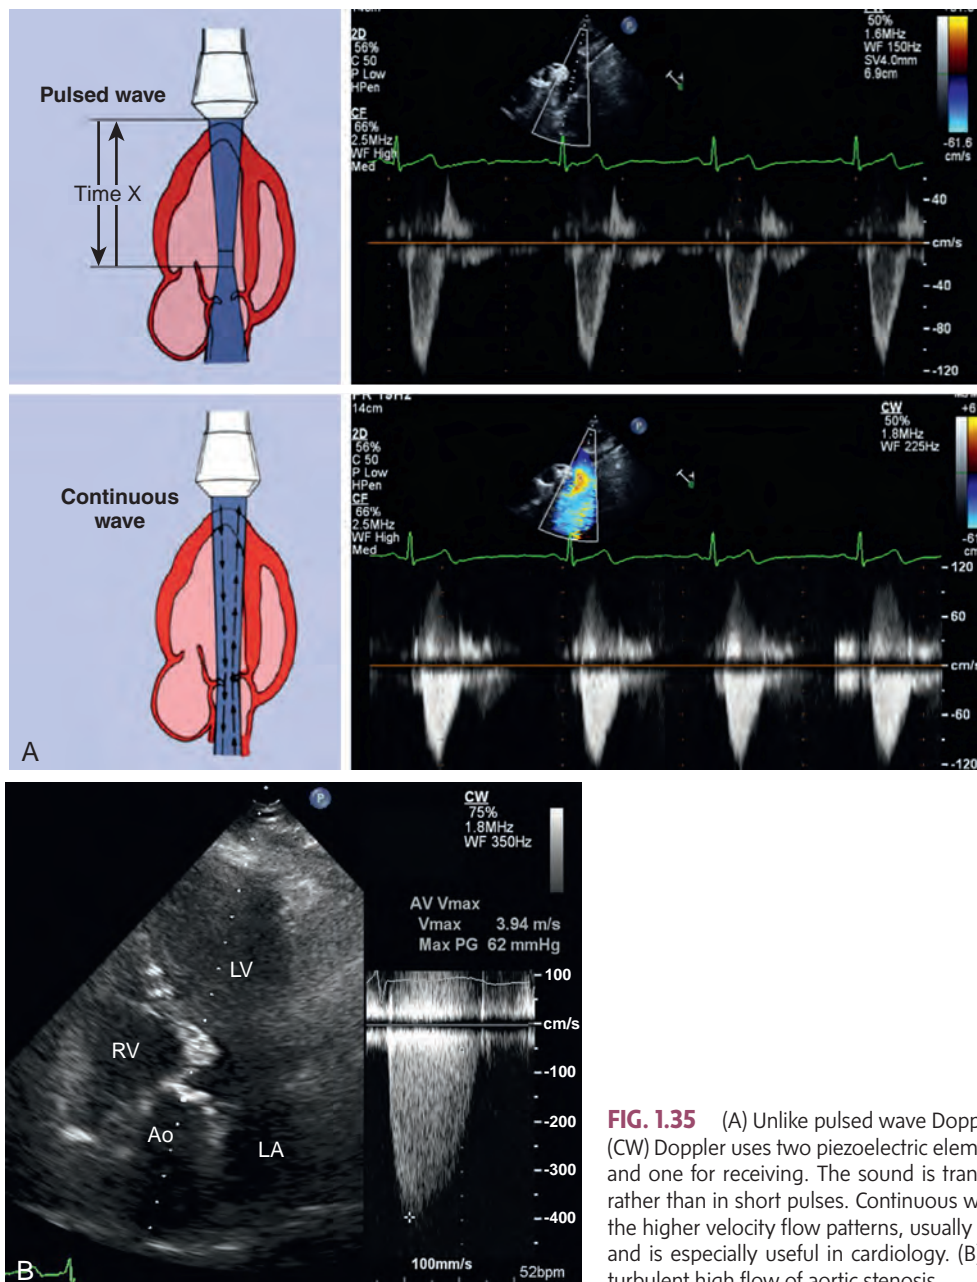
(A) Unlike pulsed wave Doppler, continuous wave (CW) Doppler uses two piezoelectric elements: one for sending and one for receiving. The sound is transmitted continuously rather than in short pulses. Continuous wave is used to record the higher velocity flow patterns, usually greater than 2 m/sec, and is especially useful in cardiology. (B) CW example of the turbulent high flow of aortic stenosis.
